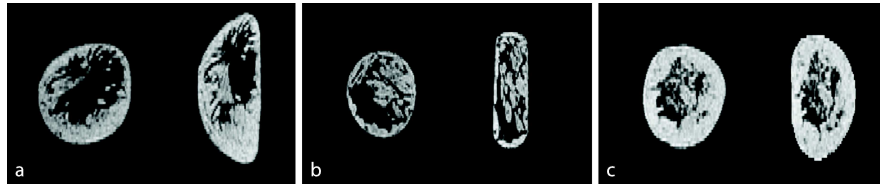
Coronal slices of the data used for evaluation for 3 volunteers (a)-(c). From left to right in each image: MRI slice before and after compression.
